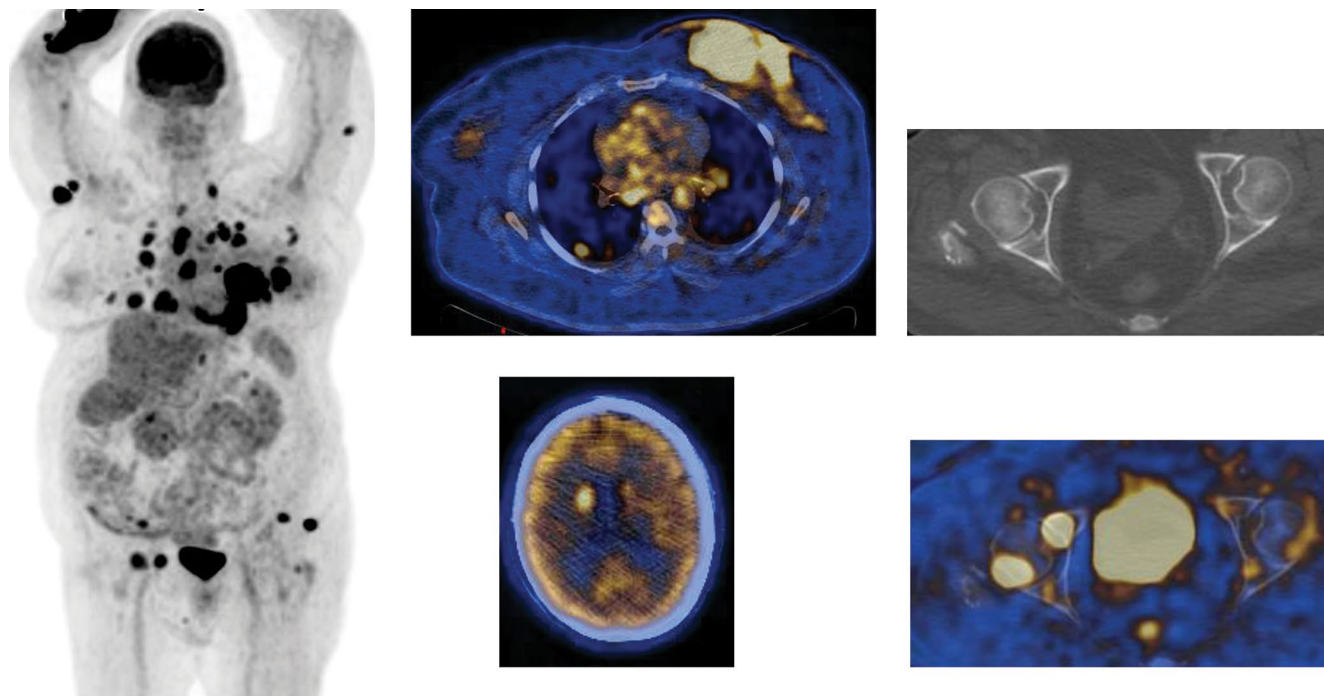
A 66-year-old female with newly diagnosed invasive ductal breast carcinoma. FDG PET/CT images show a large hypermetabolic (SUVmax 13.3) left breast mass invading the overlying skin and pectoralis muscle with multiple additional foci of activity within the breast and in the skin, multiple hypermetabolic lymph nodes in the left axilla, both side of the mediastinum, left supraclavicular and right retro-crural regions, multiple hypermetabolic lung nodules, multiple hypermetabolic bone lesions some with lytic changes and some without changes on CT, and a hypermetabolic focus adjacent to right caudate nucleus in the brain, all consistent with metastatic disease
